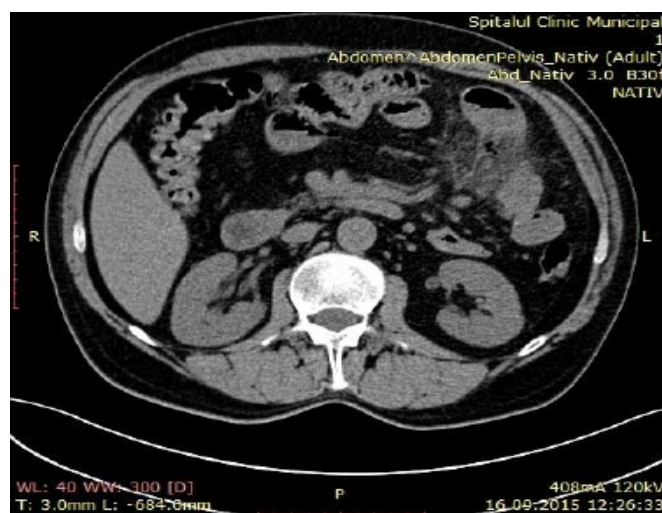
CT image showing thickening of the intestinal wall and infiltration of the fold at this level
